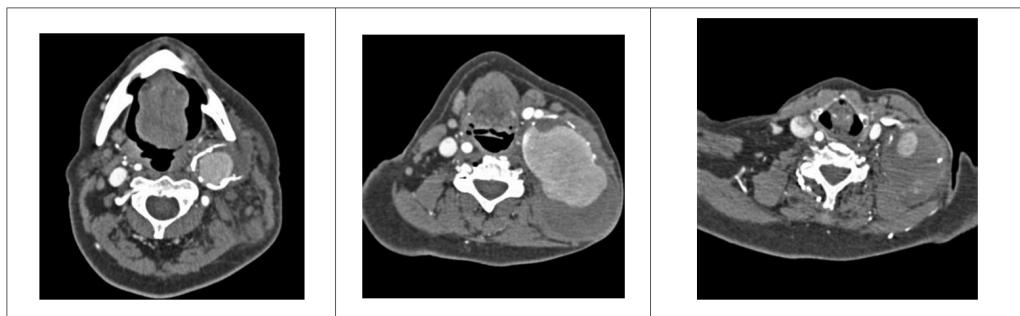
Aneurysm image in angio-CT scans; 1). At the level of the C2/C3vertebral body; 2). At the level of the C5 vertebral body, 3). At the level of the C7 vertebral body.
